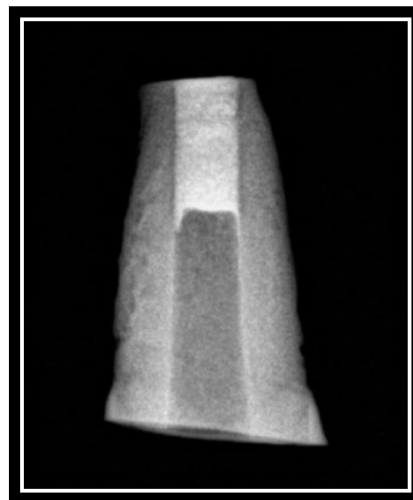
20 - APICAL PLUG VERIFIED WITH RADIOGRAPH
